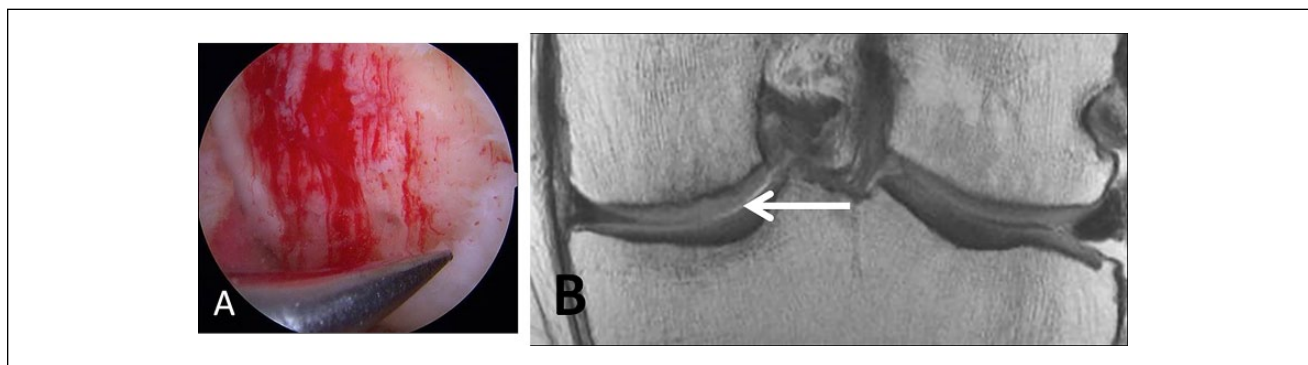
A 46-year-old male laborer who had surgical repair of a high-grade cartilage defect by a microfracture technique. (A) Microfracture or perforation of the subchondral bone. Note the filling of the defect with blood clot. (B) Coronal proton density-weighted TSE MRI at 10 months post microfracture treatment demonstrates new growth of fibrocartilaginous repair tissue over the defect.
